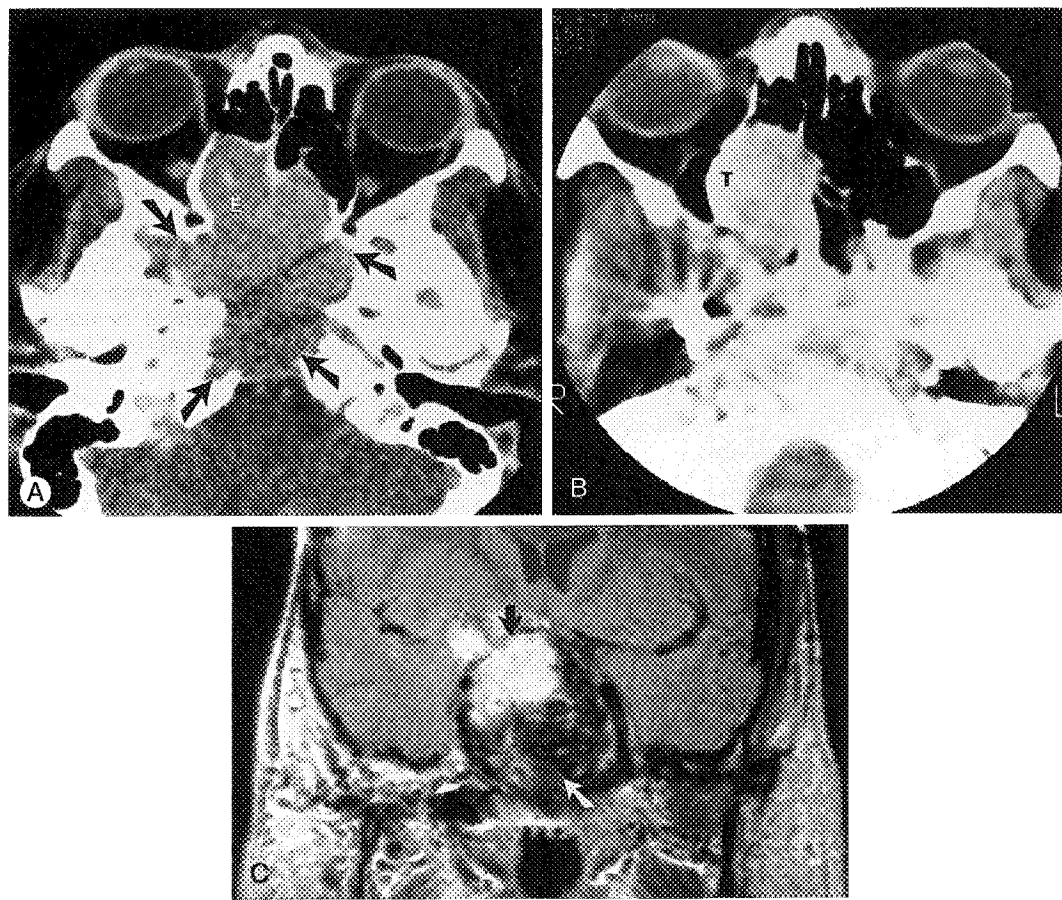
Giant cell tumor. A, Contrast-enhanced CT scan shows a destructive lesion (arrows) involving sphenoid sinus, including the clivus, and invading the posterior ethmoid air cells (E). B, Contrast-enhanced CT scan shows recurrence of tumor (T). C, Enhanced coronal T1-weighted MR image. Note enhancement of recurrent tumor (black arrow). Note the bone chips placed inside the sphenoid sinus at time of surgery (white arrow).
